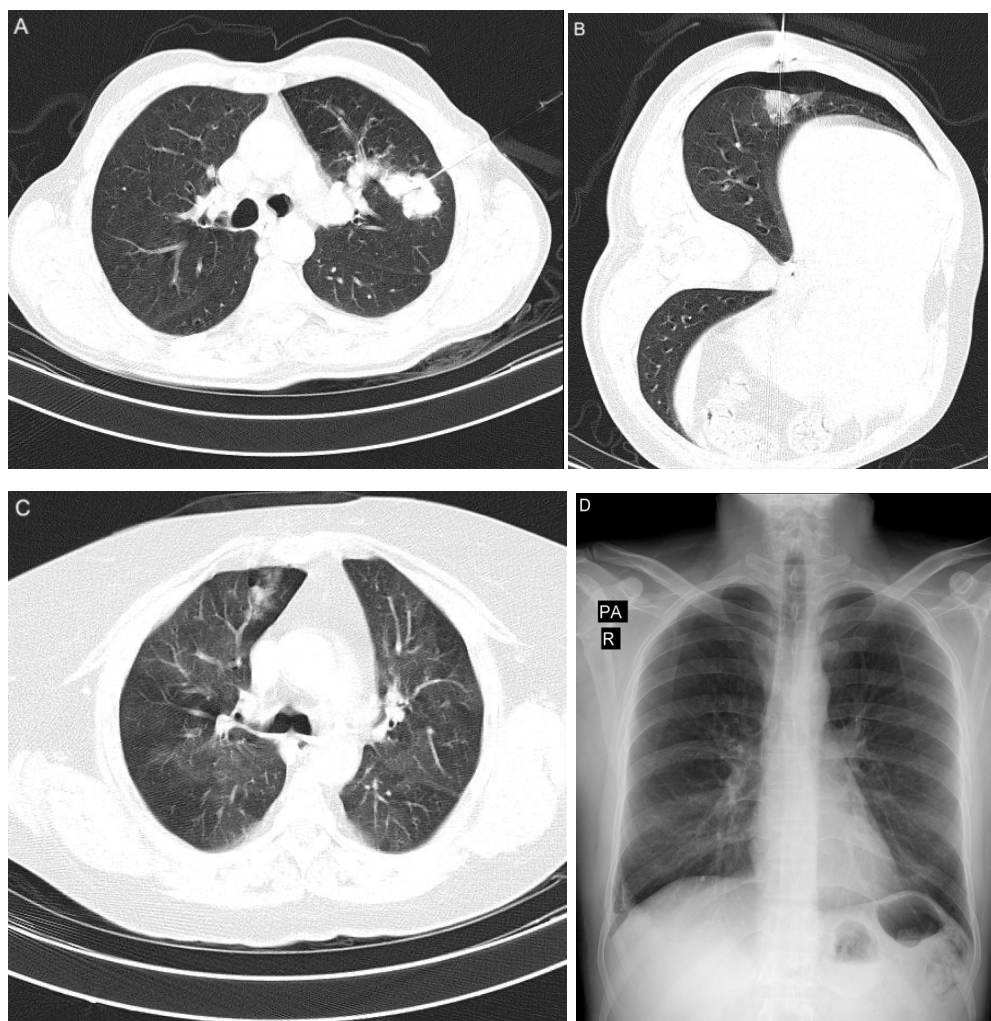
Transthoracic Needle Biopsy (TTNB) Findings: (A) TTNB of a pulmonary nodule without complications. (B) TTNB resulting in pneumothorax, the most common complication. (C) TTNB leading to perilesional hemorrhage, the second most common complication. (D) Right-sided pneumothorax diagnosed on chest X-ray (CXR) performed 3 hours post-procedure
